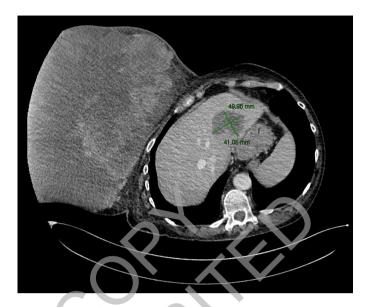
A) The computed tomography shows a giant breast mass only partially included in the FOV due to its size; B) The computed tomography shows suspected liver metastases of 48 mm x 40 mm x 45 mm.
